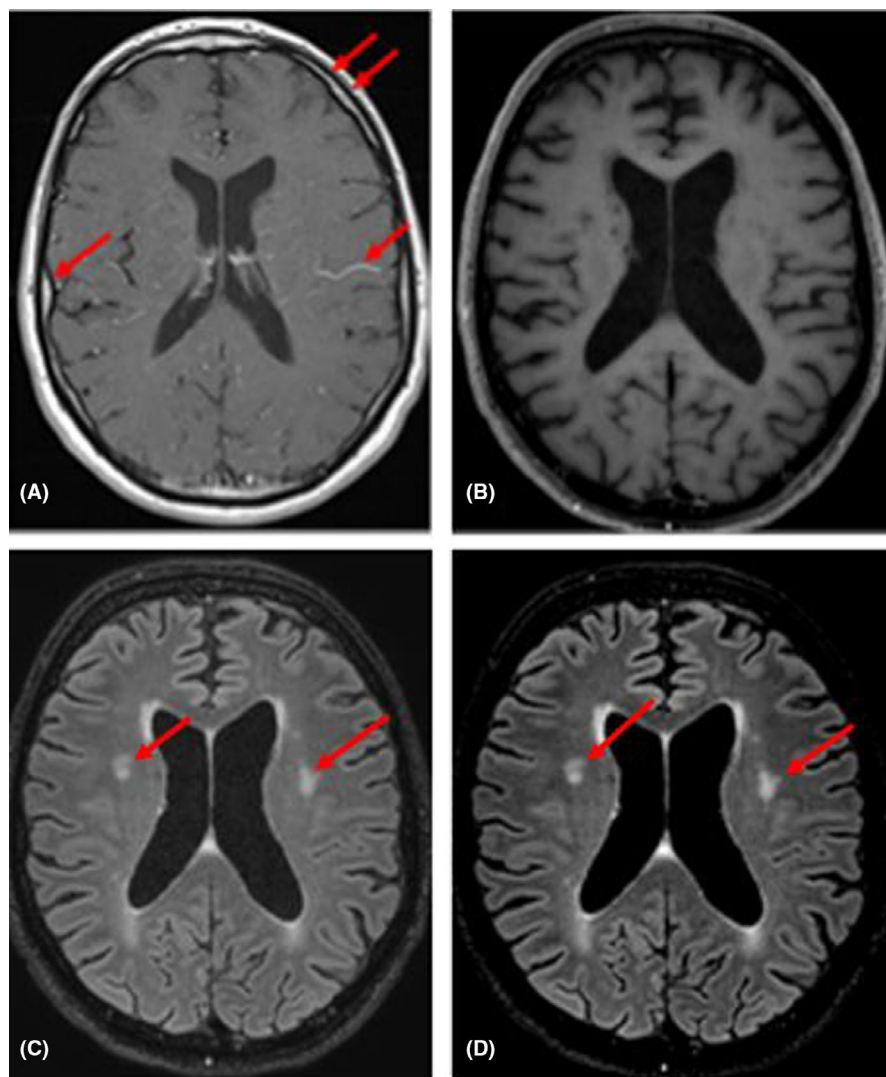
Cerebral MRI. Leptomeningeal contrast enhancement in T1 gadolinium sequence before treatment (arrow; A). Disappearance of the leptomeningeal contrast enhancement in T1 gadolinium sequence after treatment (B). Hyperintensity lesions in the supratentorial white matter in T2 FLAIR sequence before treatment (arrow; C). Stabilization of hyperintensity lesions in the supratentorial white matter in T2 FLAIR sequence after treatment (arrow; D)
